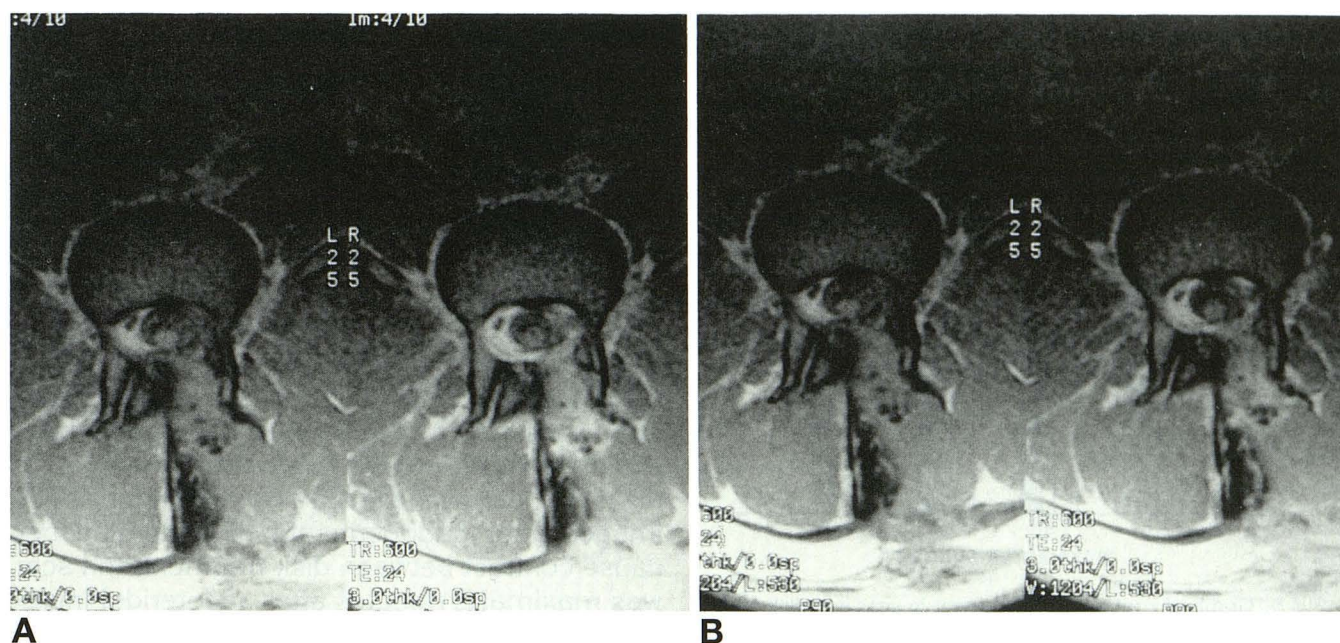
MR images 600/24/2 without (left) and with (right) intravenous contrast medium obtained from the 0.3-mmol/kg study (A) and 0.1-mmol/kg study (B). Conspicuousness of the disk fragment to the left of midline was judged about equal in the two studies.
